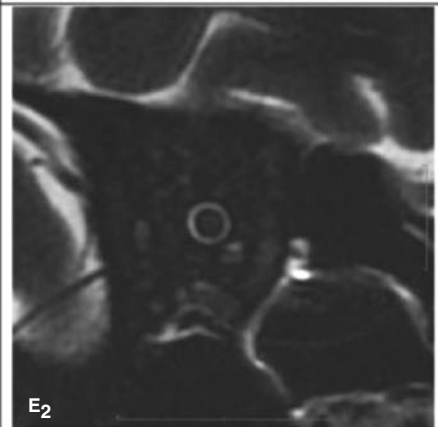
(a) Report sheet example of noninvasive quantitative ICP and translaminar cribrosa pressure difference assessment by MRI-assisted orbital subarachnoid space width [A<sub>1</sub>, A<sub>2</sub>] transversal and [B<sub>1</sub>, B<sub>2</sub>] oblique sagittal T2WI-FRFSE scan of the right and left retrobulbar optic nerve. [C<sub>1</sub>, C<sub>2</sub>] Oblique coronal T2-weighted fast recovery fast spin echo sequence (T2WI-FRFSE) image with fat suppression for demonstrating the right and left optic nerve/sheath complex taken at 3 mm behind the globe perpendicular to the optic nerve axis. (b) Report sheet example of noninvasive quantitative ICP and translaminar cribrosa pressure difference assessment by MRI-assisted orbital subarachnoid space width [D<sub>1</sub>, D<sub>2</sub>] Oblique coronal T2-weighted fast recovery fast spin echo sequence (T2WI-FRFSE) image with fat suppression for
